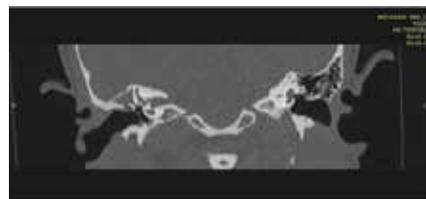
Left Ear Cholesteatoma : Coronal high resolution CT image (bone window) of temporal bone showing large cholesteatoma of left ear causing erosion of scutum, ossicles and tegmen tympani
